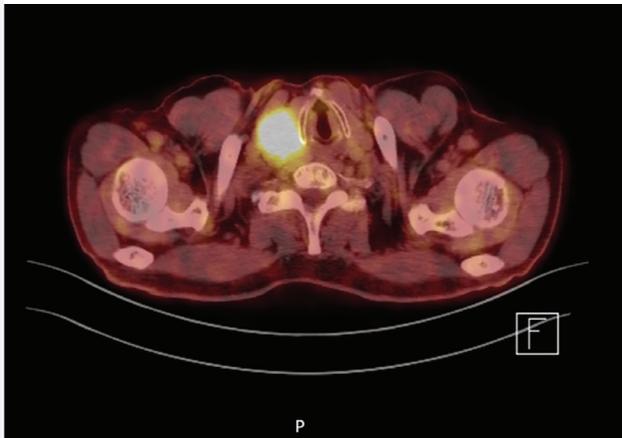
PET/CT findings: There is a hypermetabolic mass lesion in the right lobe of the thyroid gland, hypodense in nature, measuring 4.6x3.5 cm at its widest, with heterogeneous characteristics (SUV_{max} : 7.7)
